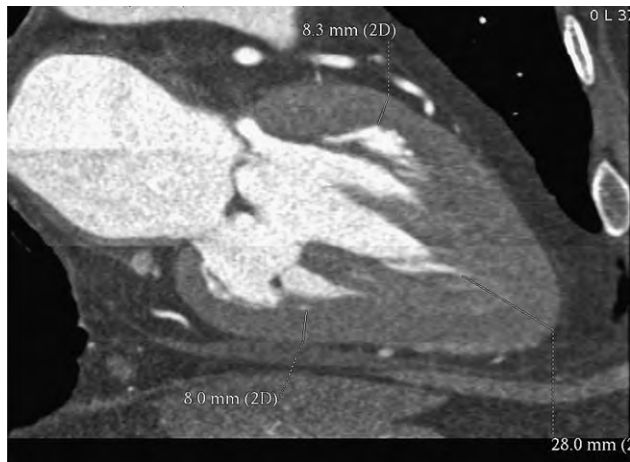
All cardiac structures including papillary muscles are well visualized in this contrast computed tomographic reconstruction, which demonstrates apical hypertrophy. The anterior and inferior walls have normal end-diastolic wall thickness (8.3 and 8 mm, respectively), while the apex shows severe hypertrophy (28 mm) on cardiac CT.
